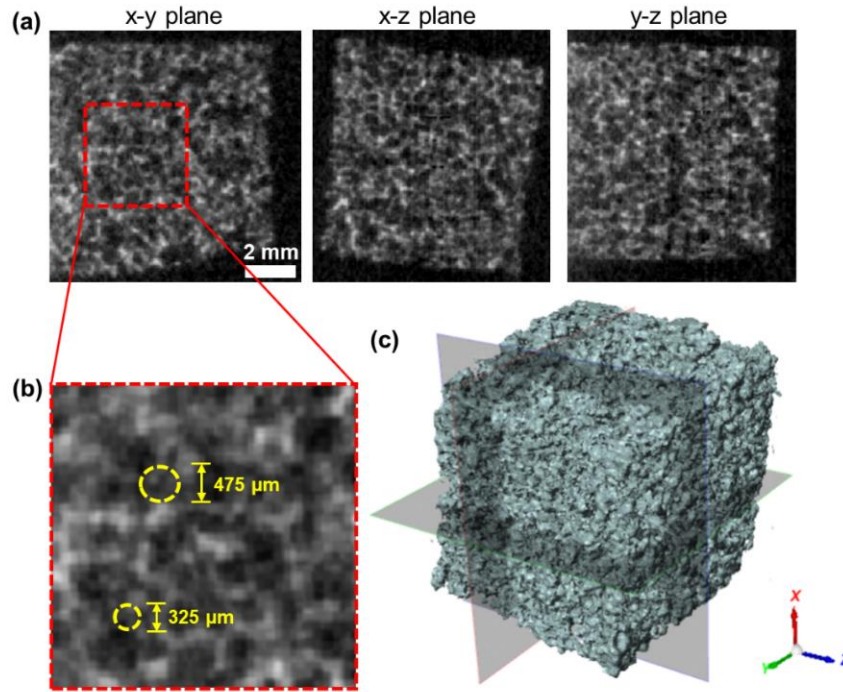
μ -CT images showing the microstructure of SMP foam: (a) 2D image slices on orthogonal planes, (b) zoomed-in area of the 2D image slice on the x - y plane, demonstrating the typical pore sizes of the SMP foam, and (c) the visualization of the reconstructed 3D geometry of the cubic SMP foam (10 mm by 10 mm by 10 mm).
